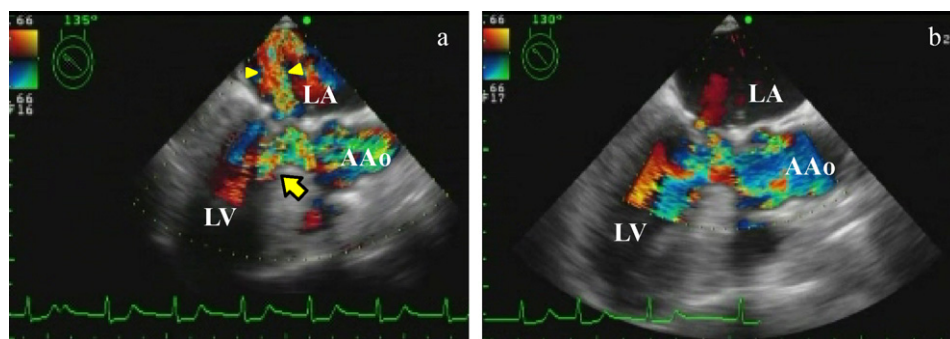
(a) Severe mitral regurgitation (arrow head) and obstruction of the left ventricular outflow tract with mosaic color flow (arrow) detected by intraoperative transesophageal echocardiography (IOTEE). (b) Obstruction of the left ventricular outflow tract improved after volume loading and stopping catecholamine, and then mitral regurgitation disappeared. AAo, ascending aorta; LA, left atrium; LV, left ventricle.
